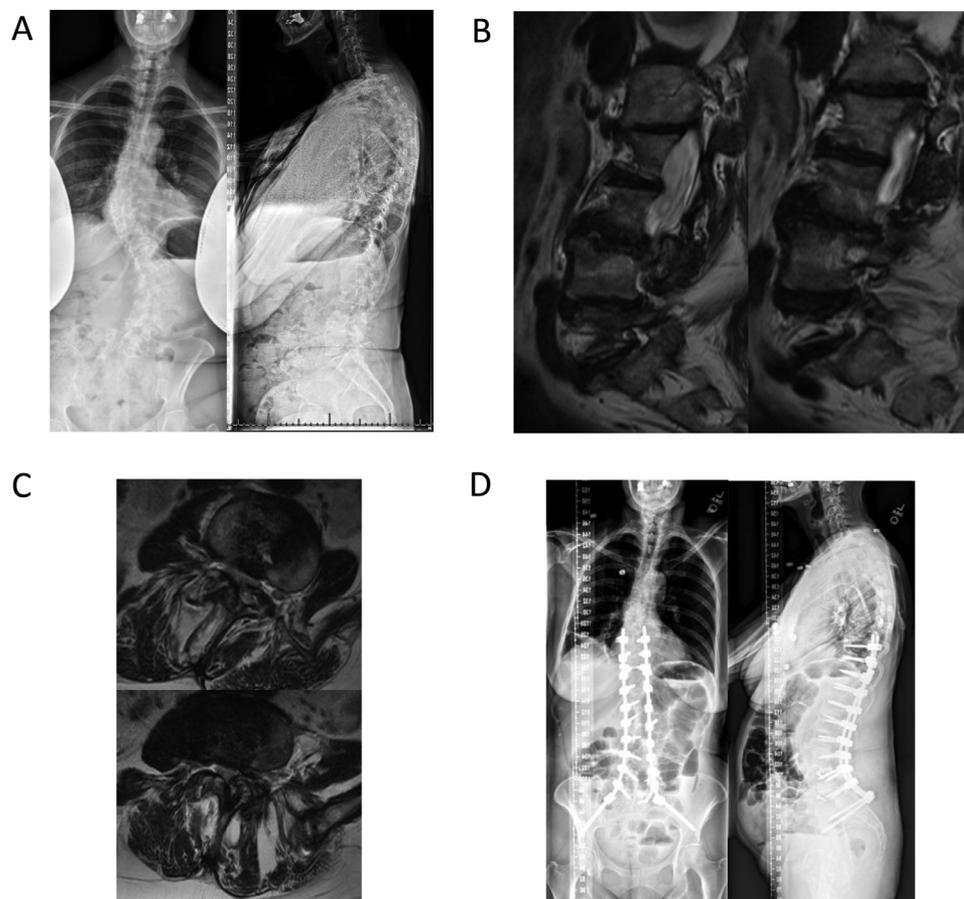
Preoperative standing scoliosis images (A) and preoperative magnetic resonance imaging (B and C) of a 64 years old female with degenerative scoliosis. In the year prior, she complained of debilitating leg pain which radiated down her bilateral legs (L > R) to the anterolateral thighs and great toe causing standing and walking intolerance. Magnetic resonance imaging demonstrated severe central stenosis at the L2/3 and L3/4 levels with severe multilevel foraminal stenosis at L4/5 and L5/S1 (B and C). She underwent a combined front-back approach to best correct her sagittal plane deformity, lumbar decompression, and fusion of the unstable segments (D). Postoperatively she noted complete relief of her back and leg symptoms. Clinical pearls: Significant coronal and sagittal plane malalignment (Cobb angle 75°, Coronal Imbalance 5 cm, SVA 0 cm, PT 26°, LL 26°, PI 54°, PI-LL 22°) with segmental instability with rotatory subluxation and lateral listhesis. This resulted in significant central and foraminal stenosis (B and C), Surgical goals are restoration of sagittal plane (20° lordosis) with additional correction of her PT due to a retroversion of her pelvis due to compensation. We chose an anterior releases and lumbar interbody fusion to restore lumbar lordosis, followed by direct decompression with laminectomy, foraminotomy and Ponte osteotomies to increase flexibility, with a final instrumented from T9-iliac (D). Final correction leads to a balance spine in the coronal and sagittal plane (CI 2.5 cm, SVA 0 cm, LL 48°, PT 20°, PI-LL 6°).
